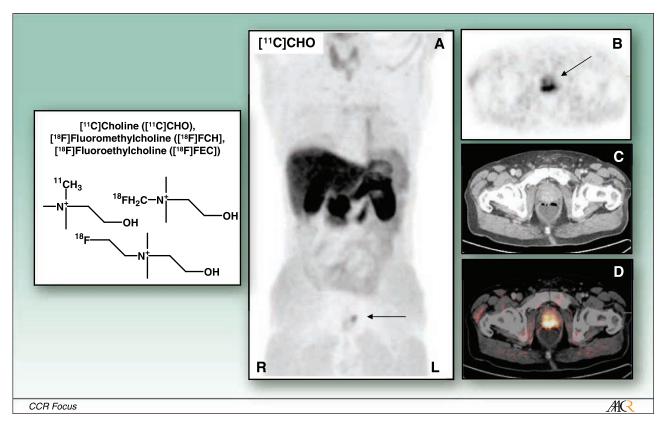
[¹¹C] Choline. [¹¹C] Choline-PET/CT of a patient with prostate cancer. Intense focal tracer uptake can be detected in the prostate gland. No further radioactivity "hotspots" (lesions) are visualized, indicating no present lymph node or distant metastases. *A,* maximum intensity projection of [¹¹C] choline-PET. *B,* transaxial section of [¹¹C] choline-PET. *C,* corresponding transaxial section of CT. *D,* fused image ([¹¹C] choline-PET/CT).
